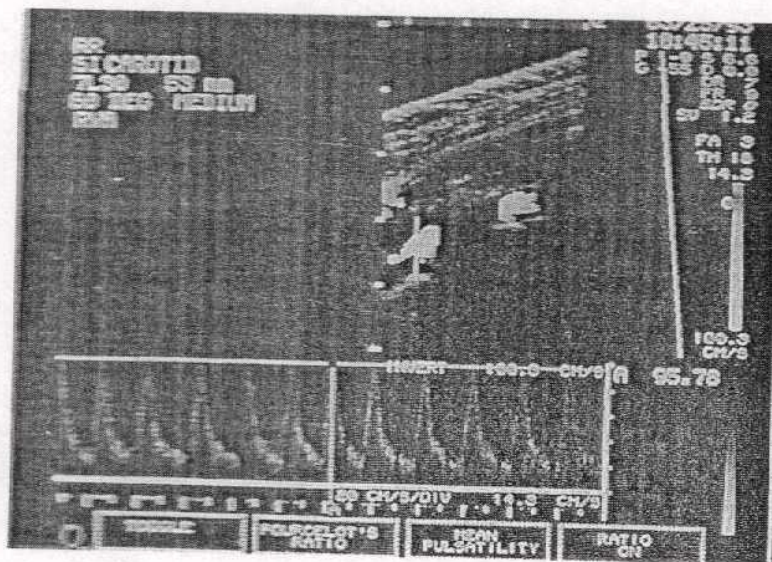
Vertebral arteries in left subclavian steal. A) Antegrade Doppler flow signal in Rt vertebral artery. (Quoted from *Diagnostic Ultrasound, 1998*).
